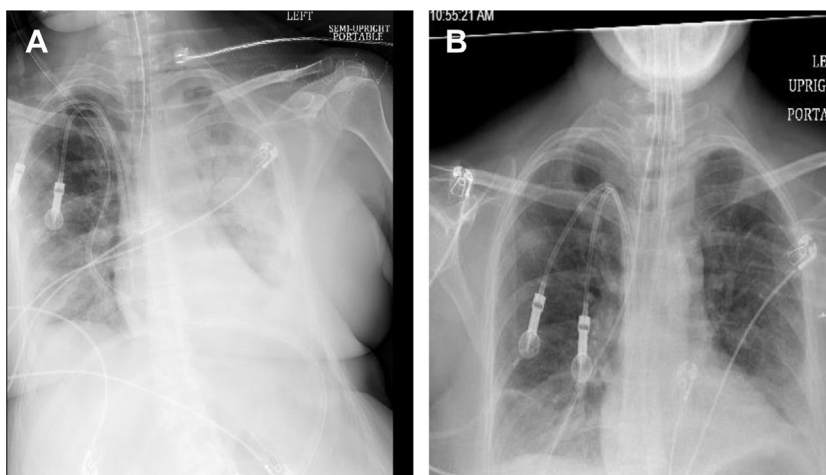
A, B, Chest radiographs from patient 6 obtained at study entry (A) and day 3 (B). At the time of study entry, the patient was mechanically ventilated, on 50% Fio₂, with positive end-expiratory pressure of 10 cm H₂O. The patient subsequently was extubated by day 4, and all supplemental oxygen support was removed by day 7.
